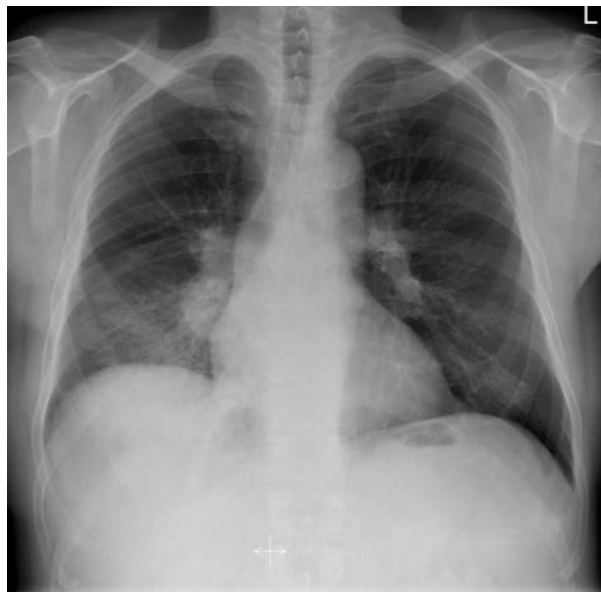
Chest X-ray. Opacities in the right lower zone and widened right hilum and mediastinum
